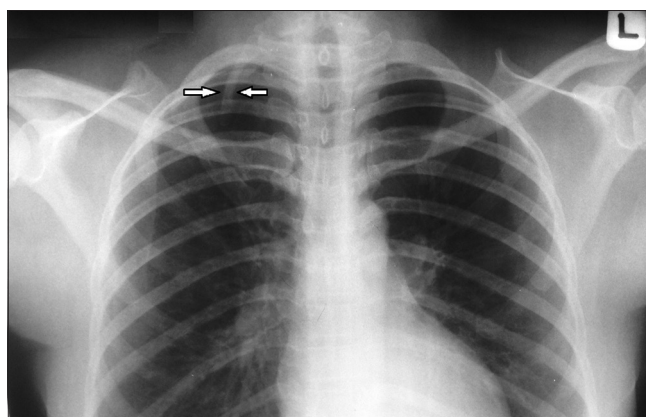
PA chest radiograph showing a right-sided cervical rib (white arrows)
